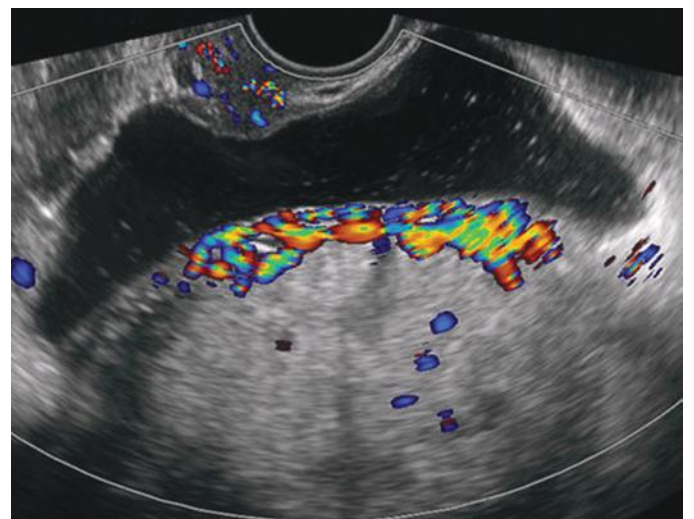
Bridging vessels. This transvaginal sonographic image at 32 weeks' gestation was obtained in the transverse plane and depicts prominent bridging vessels, shown with color Doppler, that course from the placenta to the bladder-serosal interface. They correspond to the irregularities along the bladder-serosal interface visible with gray-scale imaging.
